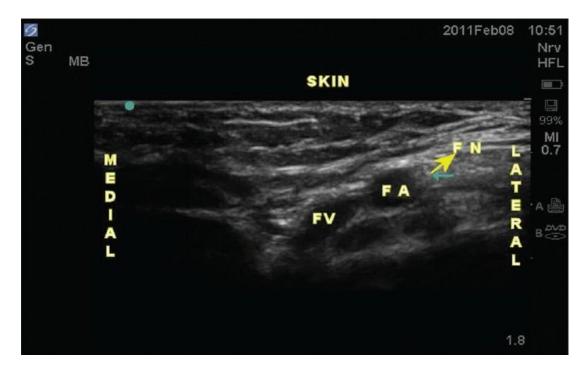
Ultrasound scan of the left femoral nerve (short axis) at the level of inguinal crease (lateral to femoral artery, deep to fascia lata, superficial to iliopsoas muscle). (4) FN: Femoral nerve FA: Femoral artery FV: Femoral vein
